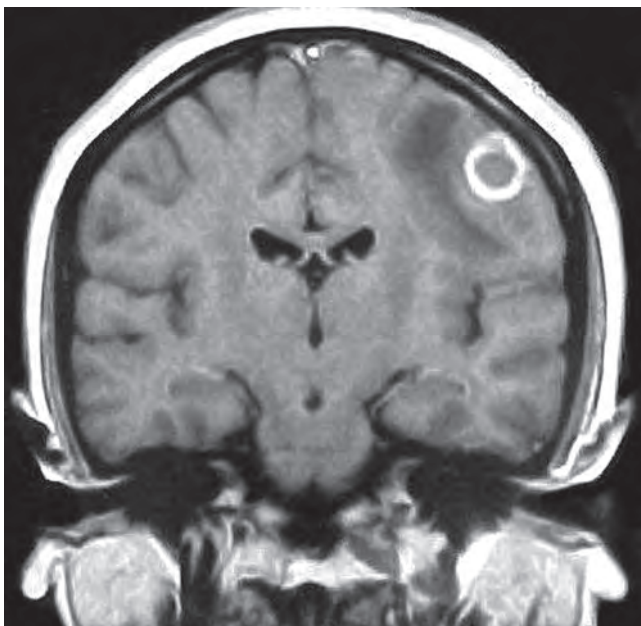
MRI coronal view showing left parietal solitary ring enhancing tuberculoma with surrounding oedema
